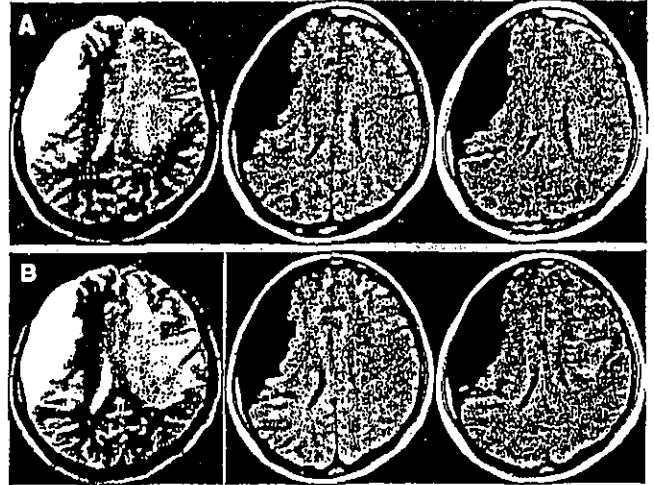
MRI scans in a representative unmethylated MGMT promoter case. This 42-year-old woman with right numbness and weakness underwent stereotactic biopsy of an AA of the left corona radiata on June 17, 1999 (A). After radiation (60 Gy) and three courses of chemotherapy (ACNU/interferon- β), she experienced a partial seizure. MRI revealed tumor progression (B). The right extra-axial lesion is an arachnoid cyst.
